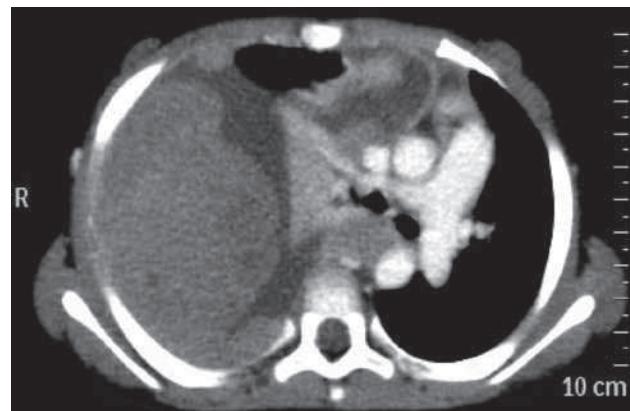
Chest CECT (contrast enhanced computed tomography): Axial view at the level of carina, that shows the presence of a solid mass occupying the right hemithorax causing lung atelectasis at the hilum and significant contralateral mediastinal shift of major vessels and airway.
